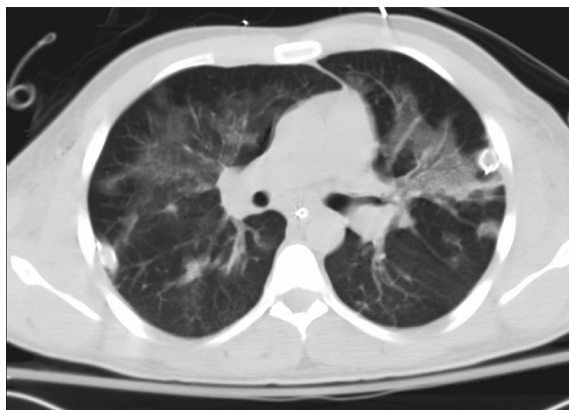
Initial computed tomography scan, 5 days after injury—case 3.
